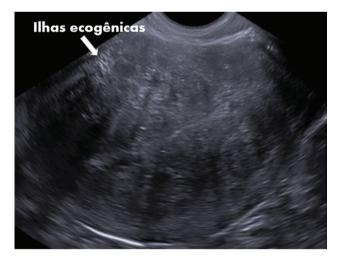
Longitudinal view of the uterus obtained by ultrasound in B-mode. Echogenic islands in the anterior wall of the myometrium (white arrow).
